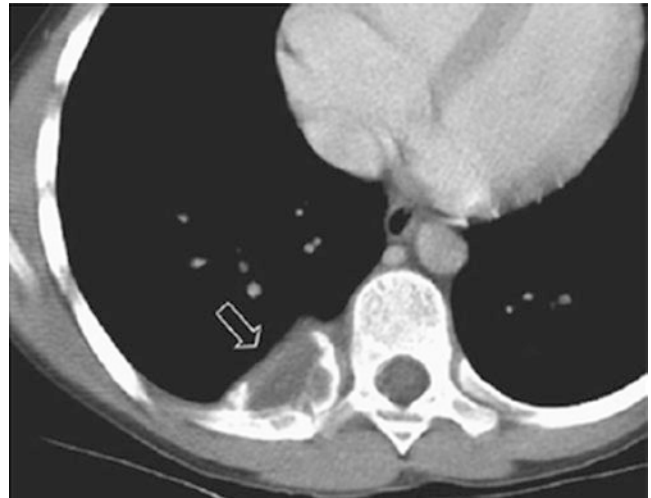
A 12-year-old boy who presented with right lower thoracic pain. Enhanced axial CT image shows a mass (*arrow*) composed of both soft tissue and osseous components. Surgical pathology of this mass was consistent with osteosarcoma
